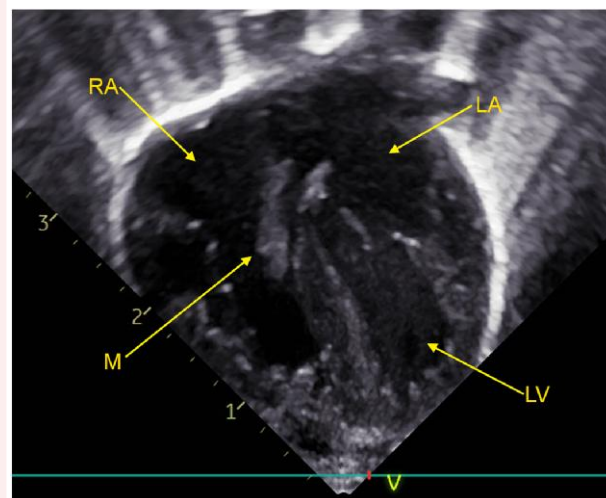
Apical four-chamber view showing mass (M) in the right atrium on the day of diagnosis. RA, right atrium; LA, left atrium; and LV, left ventricle.
